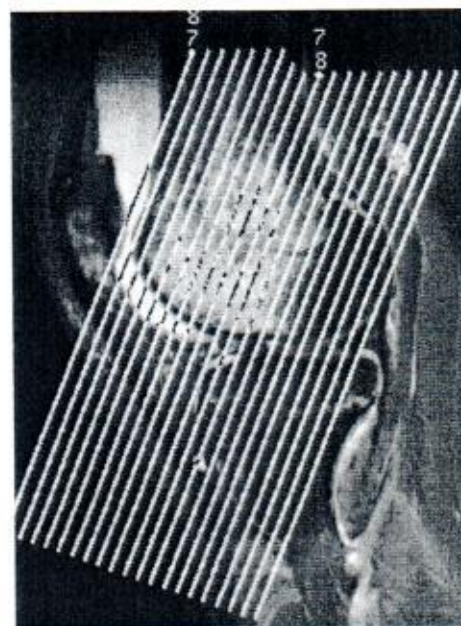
Acute primary patellar dislocation with a sagittal MR STIR sequence. The typical bone marrow lesion is demonstrated in the lateral femoral condyle. To visualize most of the osteochondral lesions on MR imaging, transaxial as well as oblique coronal sectioning (shown) is necessary
